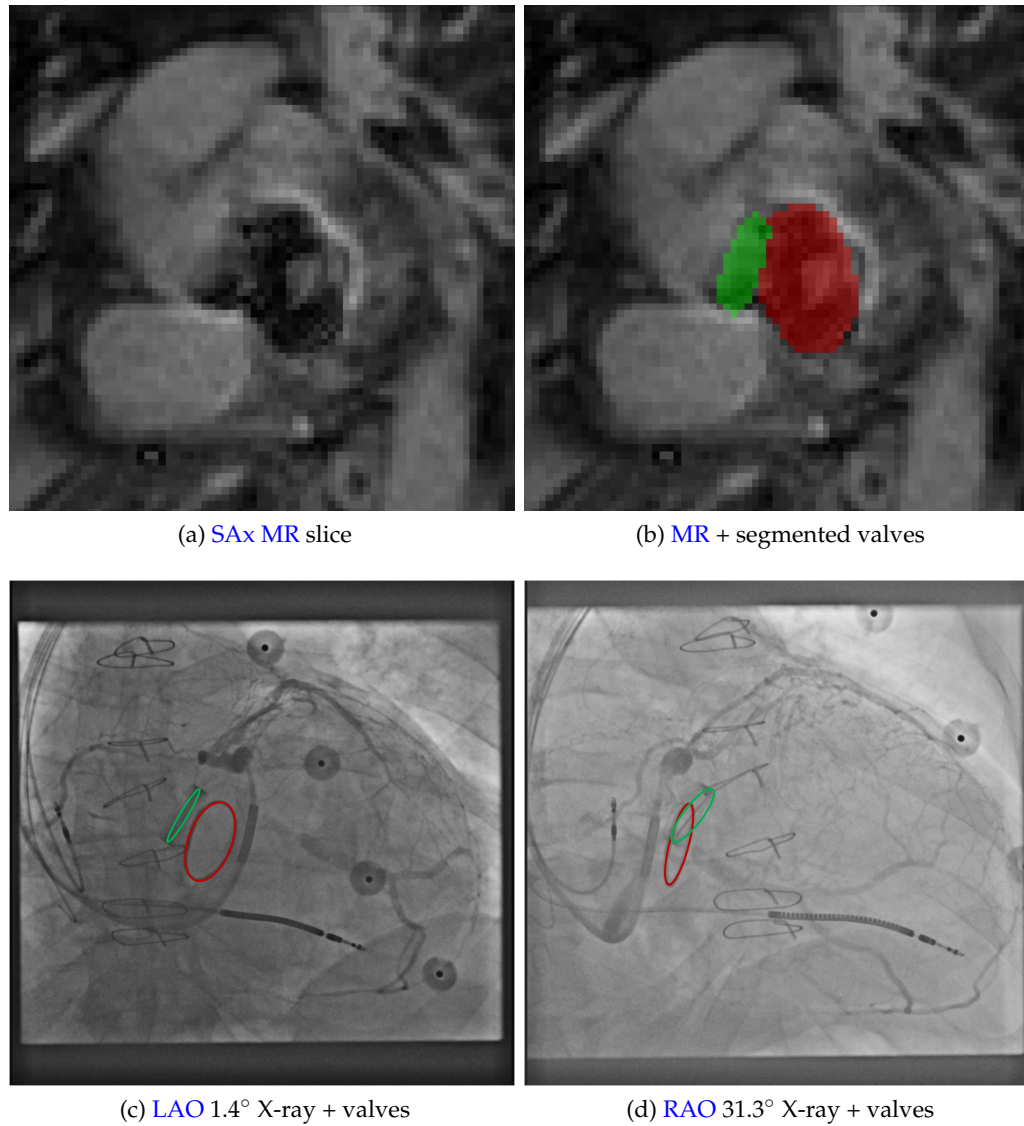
Artificial valve extraction. (a) MRI slice showing artificial aortic and mitral valves. (b) MRI slice showing segmented aortic (green) and mitral (red) valves. (c) LAO 1.4° and (d) RAO 31.3° X-ray views with the aortic and mitral valves overlaid.
